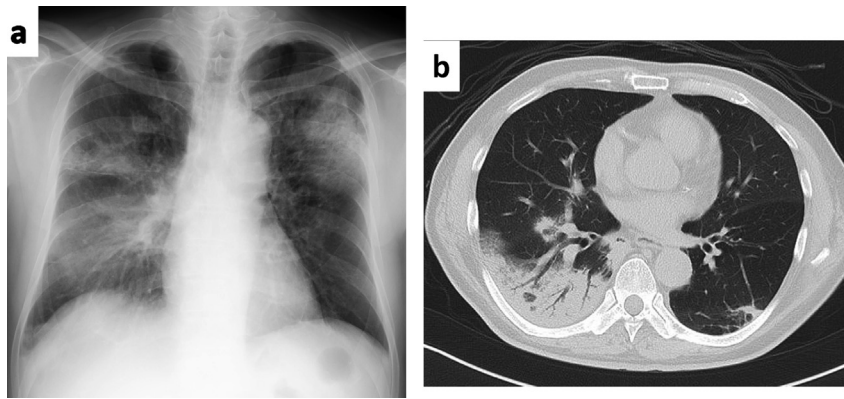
a) Chest X-ray showed bilateral infiltration without pleural effusion and cardiomegaly. b) Chest computed tomography indicated non-segmental patchy shadow and consolidation with air bronchogram.
